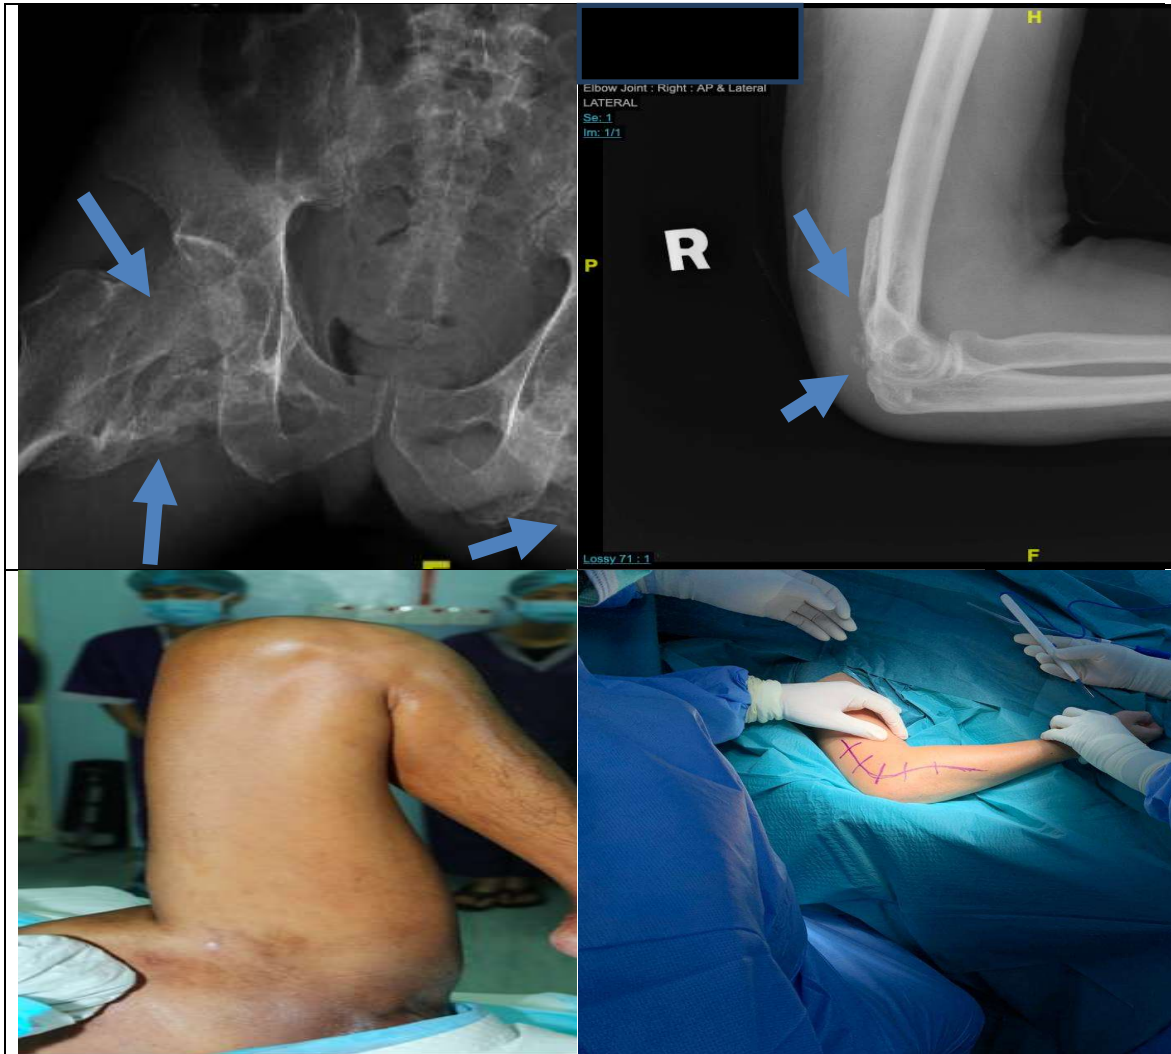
Plain X-ray of the first case showing Heterotopic Ossification (HO) of bilateral hip (figure 1a) and elbow (figure 1c). The HO location on the respective X-rays are showed by the blue arrows. Figure 1b and 1d showed the pre-operative condition of the respective cases.
